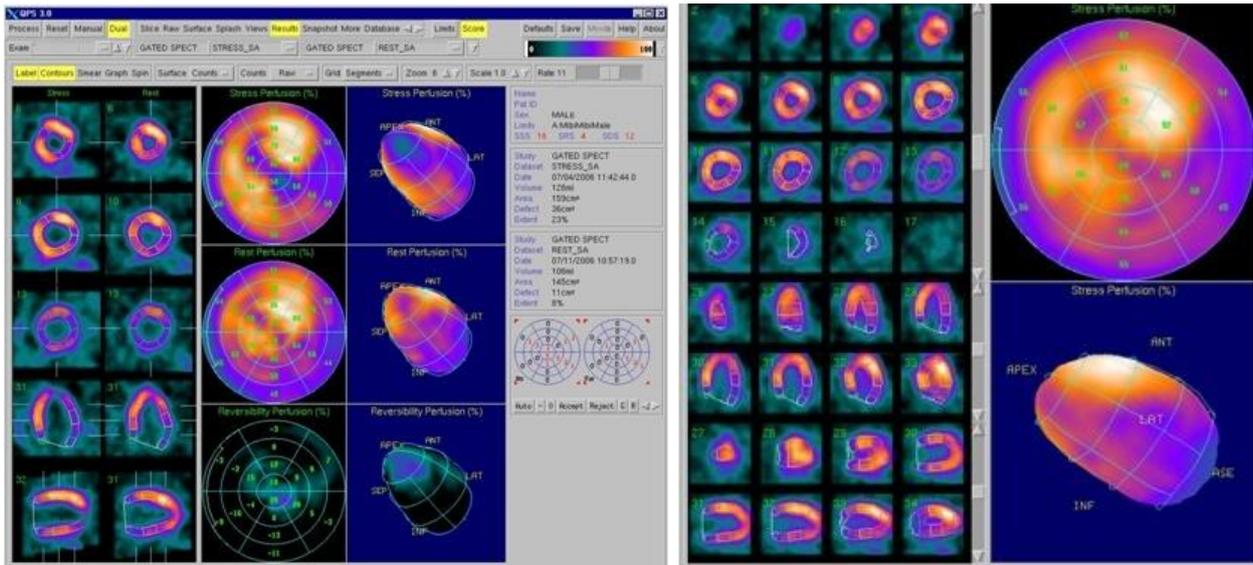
Positive perfusion scintigraphy in patient with diabetes mellitus- silent ischaemia. Left upper image- after exercise test, left lower image- rest examination, lateral wall ischaemia. On the left before treatment, on the right after treatment. (own source).
